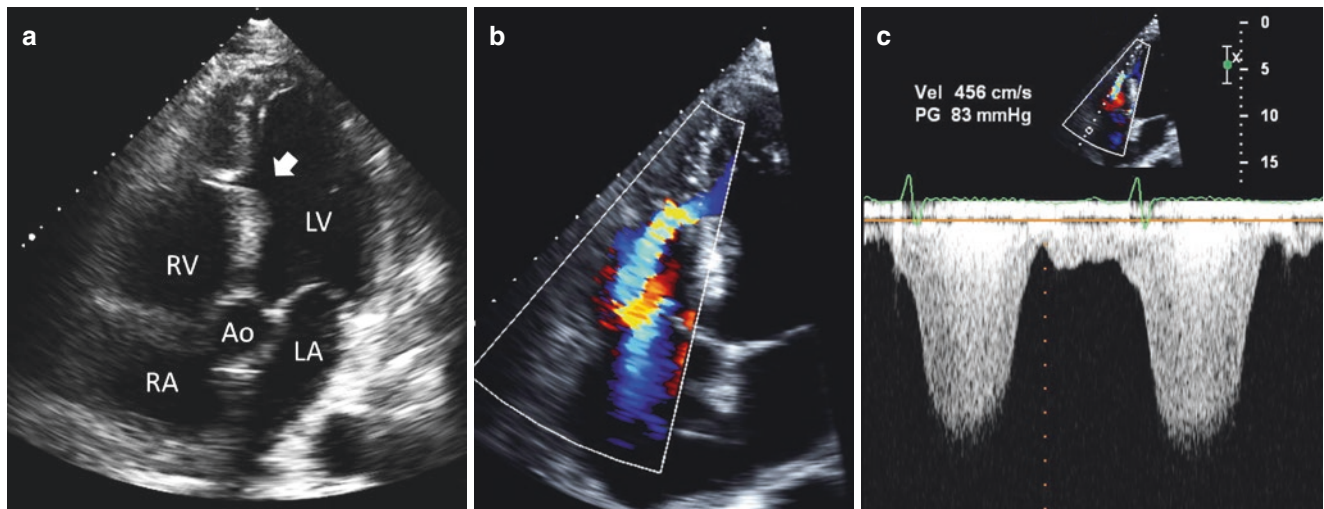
Muscular ventricular septal defect. (a) Apical five-chamber view showing a small muscular ventricular septal defect (arrow), located at the mid portion of the ventricular septum. Muscular ventricular septal defects are typically well seen in parasternal short-axis or apical views (except for the two-chamber view). In this picture, the transducer was slightly rotated clockwise and angled anteriorly from a four-chamber view, hence the visualization of the aorta. (b) Color-flow
